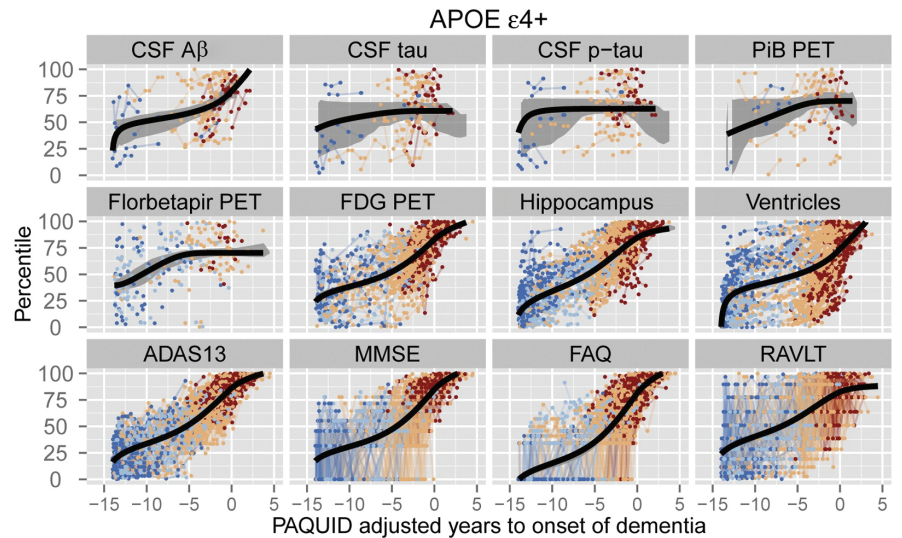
Alzheimer's Disease Neuroimaging Initiative (ADNI) apolipoprotein E (APOE) ε4 allele carriers. Each of the mean trajectories is superimposed over the subject-level observations from 570 APOE ε4 individuals, coloured by diagnosis. Colours represent diagnosis at ADNI baseline – cognitively normal (CN) in dark blue, early mild cognitive impairment (EMCI) in light blue, late mild cognitive impairment (LMCI) in light red, and Alzheimer's disease (AD) in dark red. Shaded grey regions, where visible in the top panels, represent bootstrap 95% confidence bands. Time has been adjusted using long-term "Personnes Agées Quid" (PAQUID) Mini-Mental State Examination trajectories so that time zero represents the estimated time to onset of dementia. Aβ, amyloid-β; p-tau, phosphorylated tau; PiB, Pittsburgh compound B; FDG, fluorodeoxyglucose; ADAS13, the 13-item Alzheimer's Disease Assessment Scale–Cognitive Subscale; MMSE, Mini-Mental State Examination; FAQ, Alzheimer's Disease Cooperative Study Functional Activities Questionnaire; RAVLT, Rey Auditory Visual Learning Test. Reprinted from reference 12.
